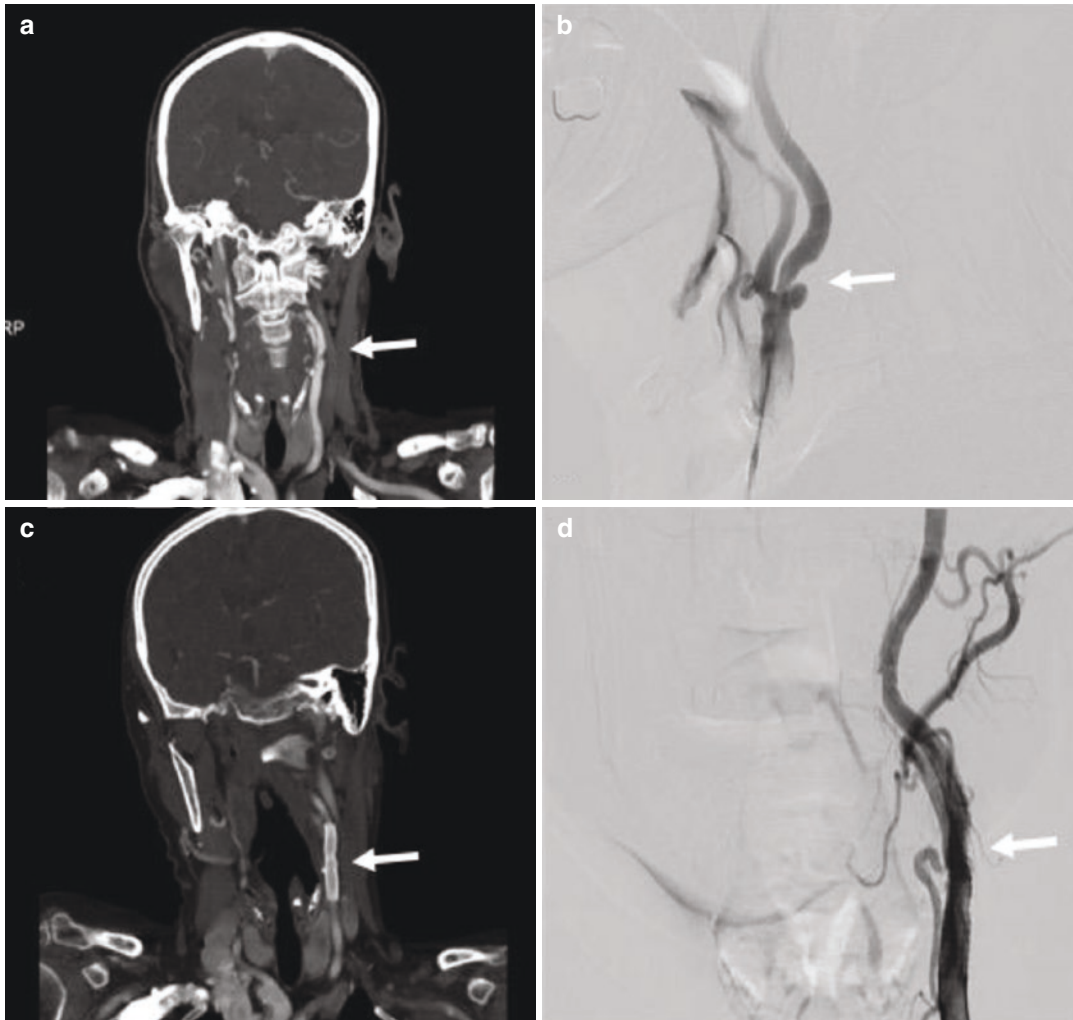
CTA and digital subtraction angiography (DSA) of the carotid arteries before and after stenting. CTA MIP image (a) and DSA (b) of the left carotid artery
